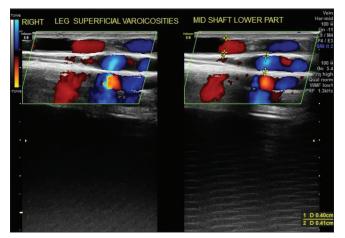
Color Doppler right leg showing varices in shaft region and incompetent perforator.
